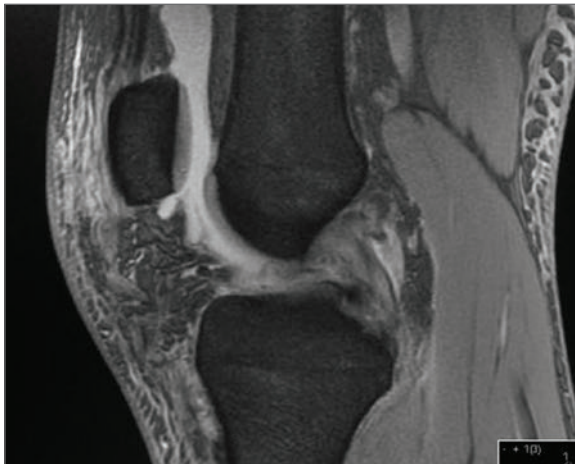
MRI scan of the sagittal view of the same knee as in ► Fig. 10.12. The image also demonstrates a complete loss of the normal fibrillar pattern of the patella tendon. In addition, a large intra-articular effusion is seen.
